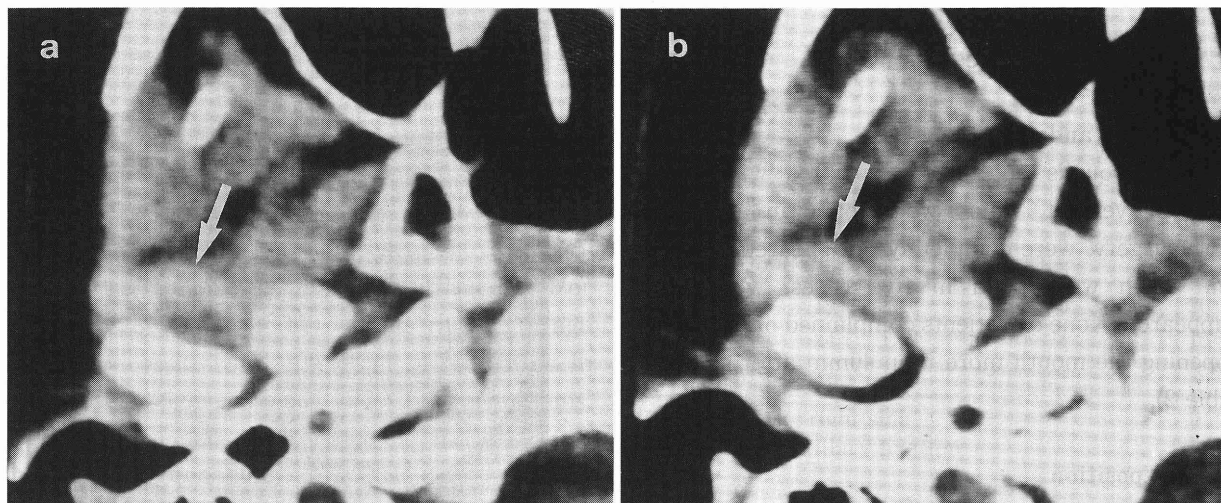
TMJ X-ray computed tomography in axial section (case 1). Pre-(a) and post-operative (b; post-op. 6 months) images. After IVRO, anteriorly displaced disc (arrow) of right TMJ was unchanged in closed mouth position.
